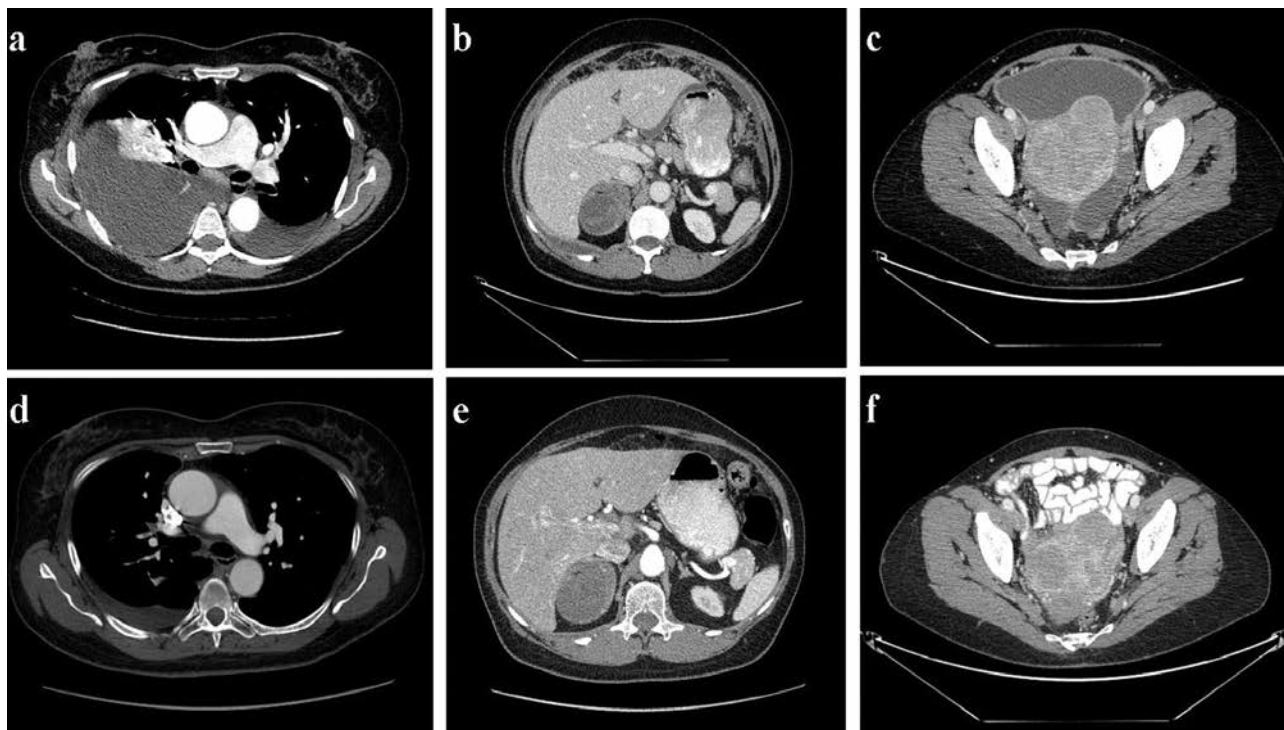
A CT-scan performed July 2008, prior to chemotherapy, showing: (a) peritoneal and bilateral pleural carcinomatosis, (b) an adrenal mass of six cm and (c) pelvic mass with ascites misinterpreted as carcinomatosis. After chemotherapy, the CT-scan of November 2009 reveals: (d) bilateral pulmonary embolism, (e) unconformity of disappearance of abdominal ascites and reduction of abdominal and pleural carcinomatosis, and (f) size stability of the right adrenal mass.
